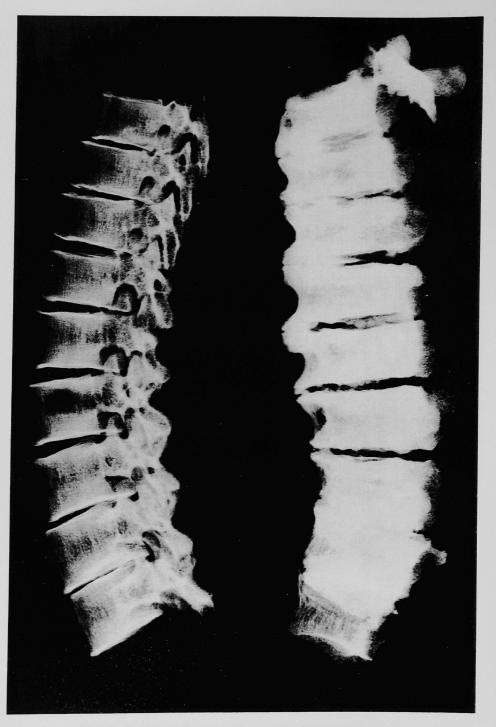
Radiograph of fluorosed spine (right) compared to normal (left).
